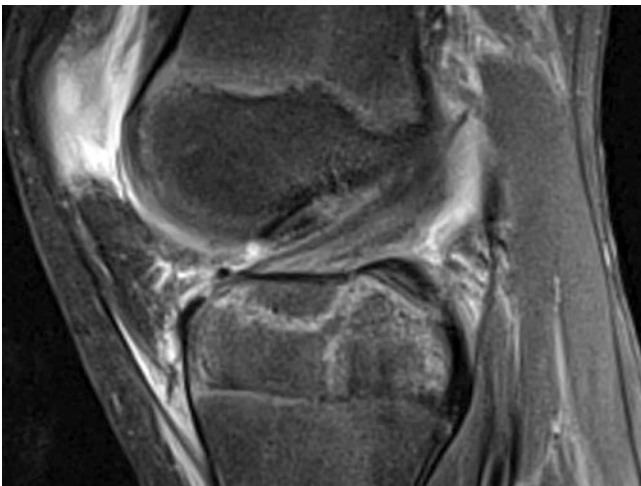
Sagittal and coronal MRI knee demonstrates high signal outlining the avulsed tibial spine
